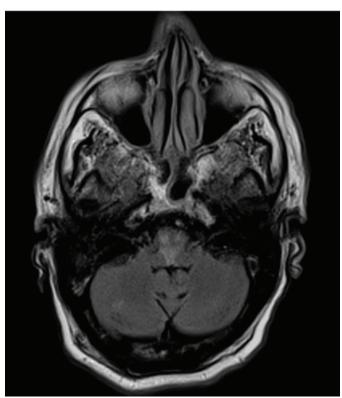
Fluid attenuated inversion recovery sequence (FLAIR) hyper intensity noted in the same region.
